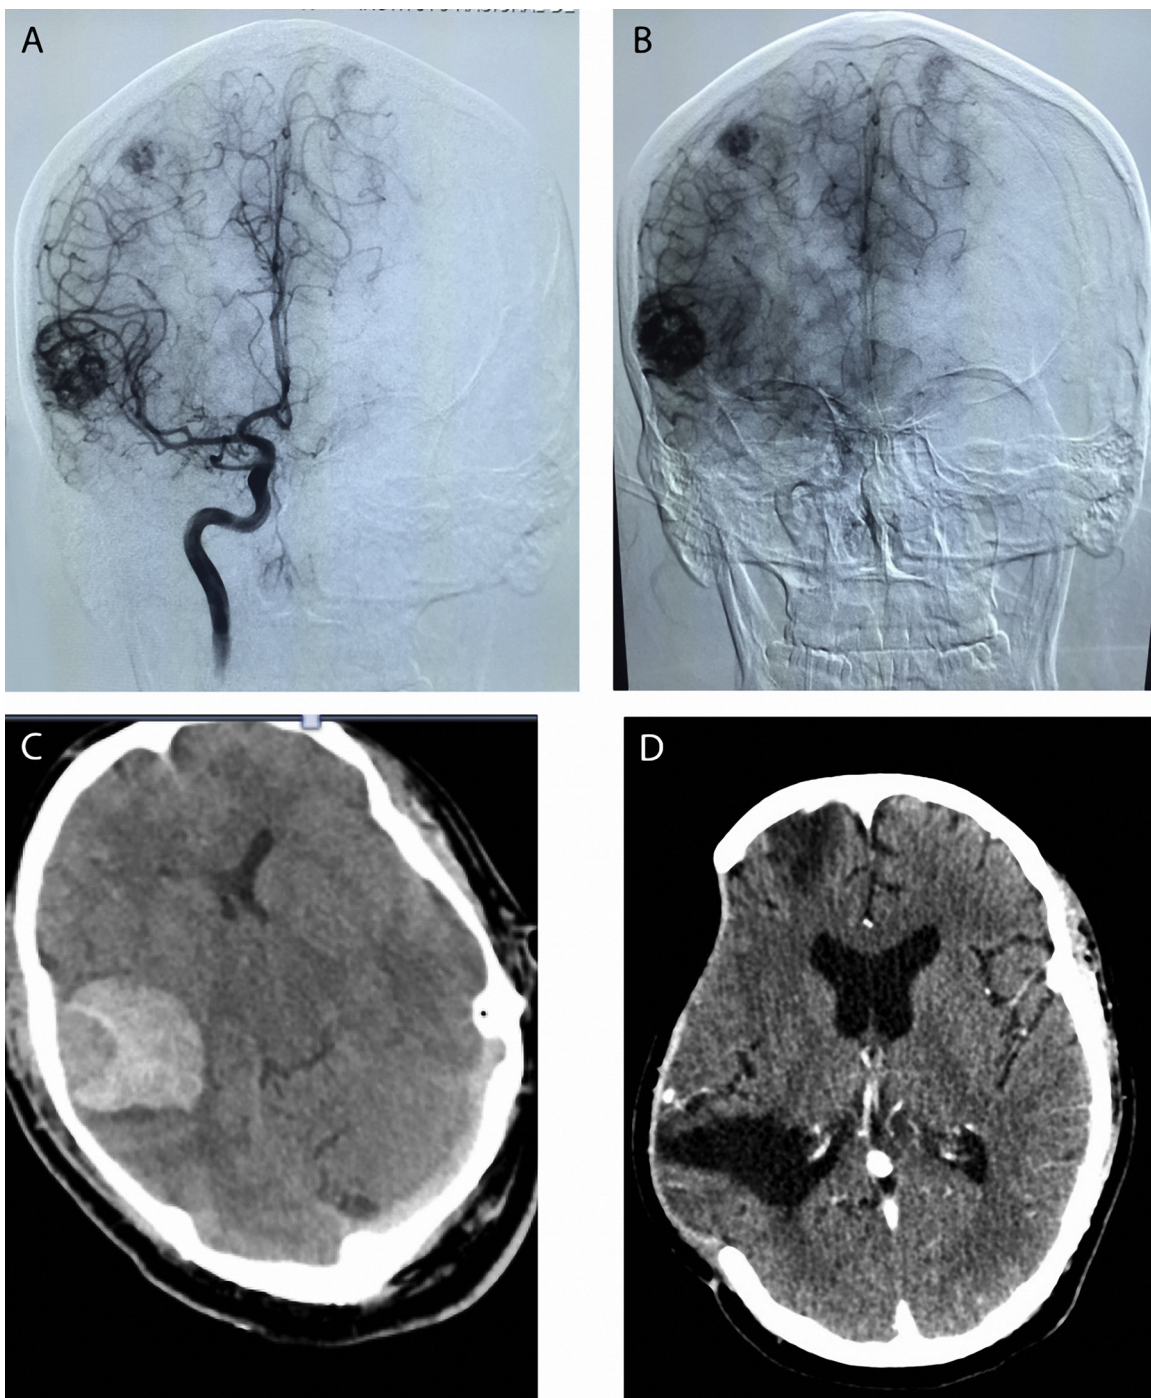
A) Posteroanterior view of cerebral angiography showed a tangle of serpiginous vessels inside the lesions; 1) one lesion was located in the temporal lobe which was supplied by the anterior and middle temporal artery of the middle cerebral artery; and 2) the second lesion was supplied by the angular artery. B) The late phase of the angiogram showed venous drainage in both lesions. C) Computed tomography (CT) showed a new hemorrhage in the lesion of the temporal lobe with an important mass effect, ventricular compression, severe cerebral edema, and midline deviation. D) Postoperative CT showed a decompressive craniectomy with a complete lesion resection.
